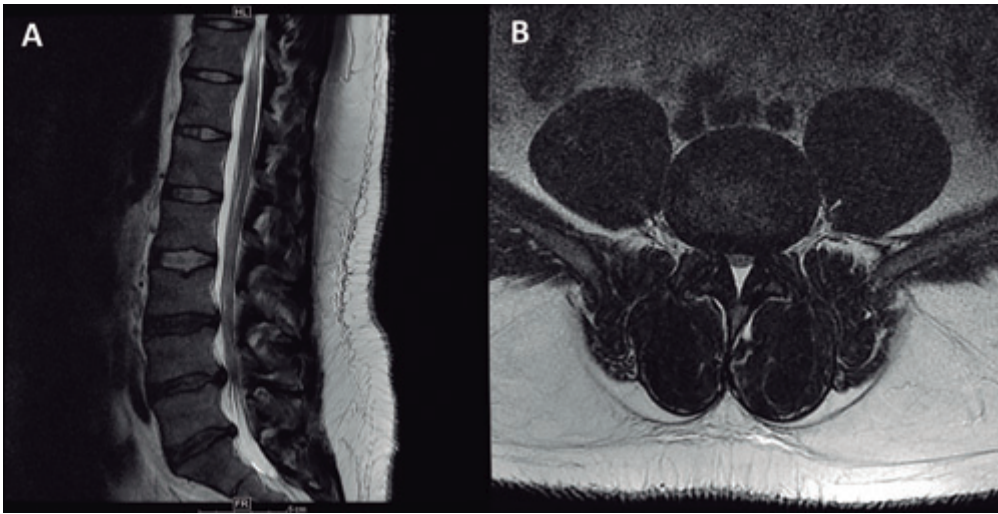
MRI of The Lumbar Spine Demonstrates Moderate Spinal Stenosis From Hypertrophy of The Facets And Ligamentum Flavum, as Well as Degenerative Disc Disease.
